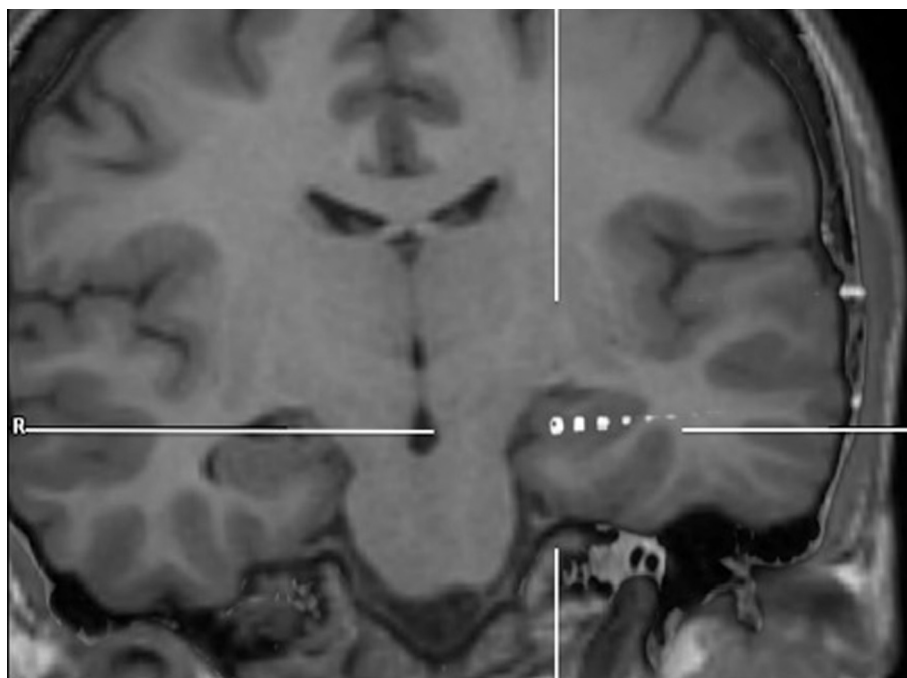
Localization of the medial contacts of the left (*) hippocampal (B) electrode of patient 2, by a MRI 3D T1 coronal slice. The white cross-bars target the contact B' n° 1, within the gyrus dentatus. Contact B' n° 4 was unambiguously located in area 1 of cornu ammonis (CA1) of the left hippocampus and was thus selected for the analysis.
